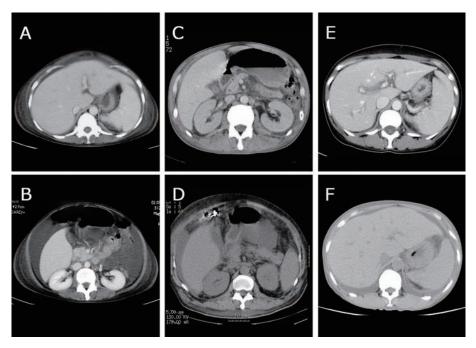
Computed tomography scans of the abdomen show marked ascites, a mild degree of hepatosplenomegaly and tiny lymphadenopathy of the para-aortic region. (*IA* & *IB*) case 1 upon first admission. (*IC*) case 2, (*ID*) case 3, (*IE*) case 4, (*IF*) case 5.
